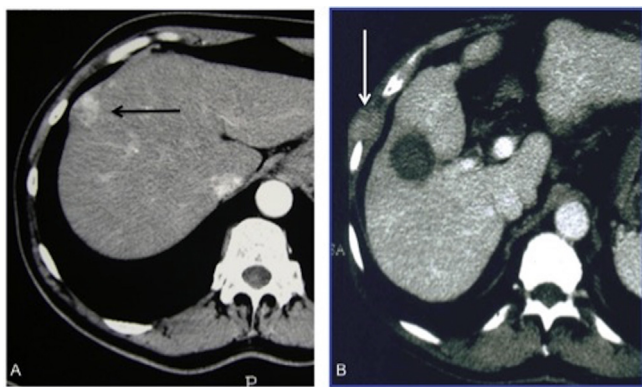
63-year-old male with a 3.1 cm subcapsular HCC. (A) Pre-RF CT (hepatic arterial phase) demonstrates a hyper-enhancing HCC in segment 8. The tumor underwent percutaneous biopsy and subsequent RF ablation using a direct puncture. (B) Subcutaneous tumor seeding at puncture site six years post-ablation. The seeding is located in both the biopsy needle and RF ablation antenna track. The seed was surgically excised, and the patient survived 7 years after surgery.
